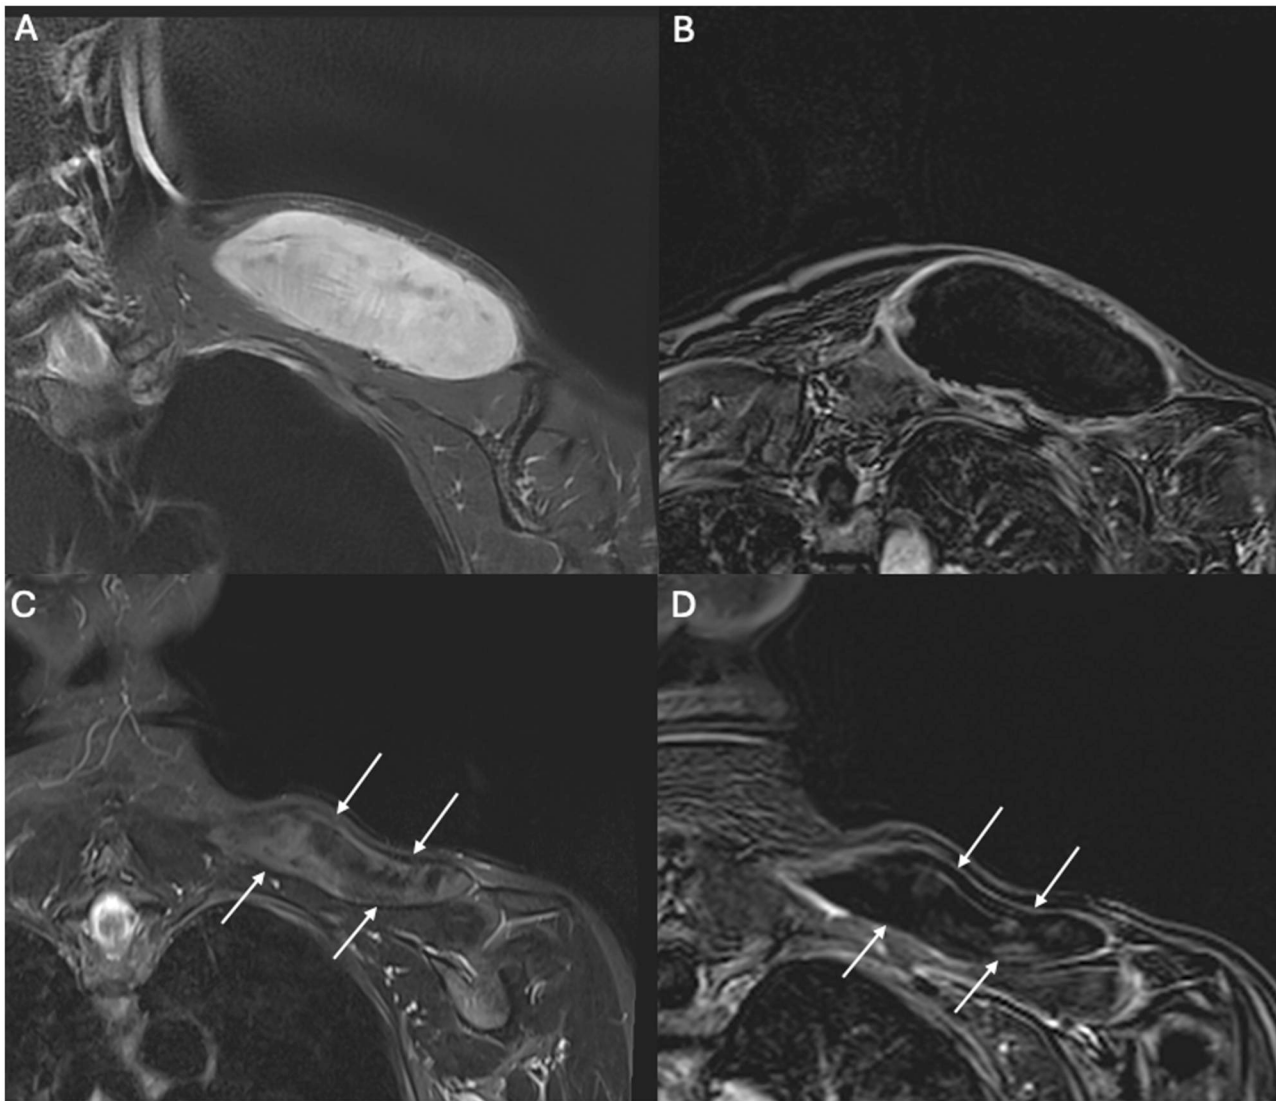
CA of a DF in the shoulder girdle. Coronal T2 Stir MRI (A) shows a 4.5X6X11.5 cm DF. Coronal contrast-enhanced MRI 6 months after CA (B) demonstrates complete necrosis of the tumour. Coronal T2 stir (C) and contrast-enhanced (D) MRI 18 months after treatment shows shrinkage and complete response. Abbreviations: CA = cryoablation; DF = desmoid fibromatosis.
